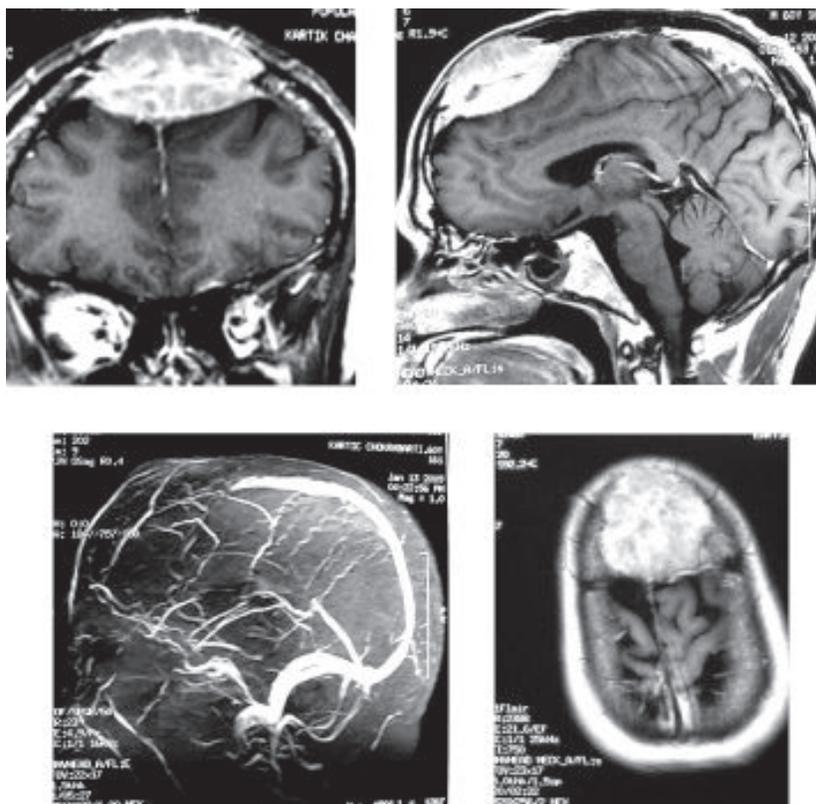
MRI of brain shows contrast enhanced lesions in different views and MRV shows obstructions of anterior part of superior sagittal sinus.
